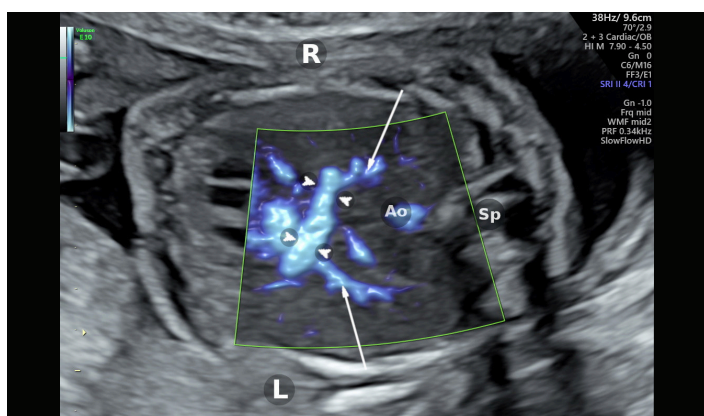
Total anomalous pulmonary venous return (white arrows) draining in a confluence situated behind the atria (white arrowheads), as demonstrated with SlowflowHD. Please note that the region of interest (ROI – "green Doppler box") does not include the ventricular walls, in order to reduce artifacts.
